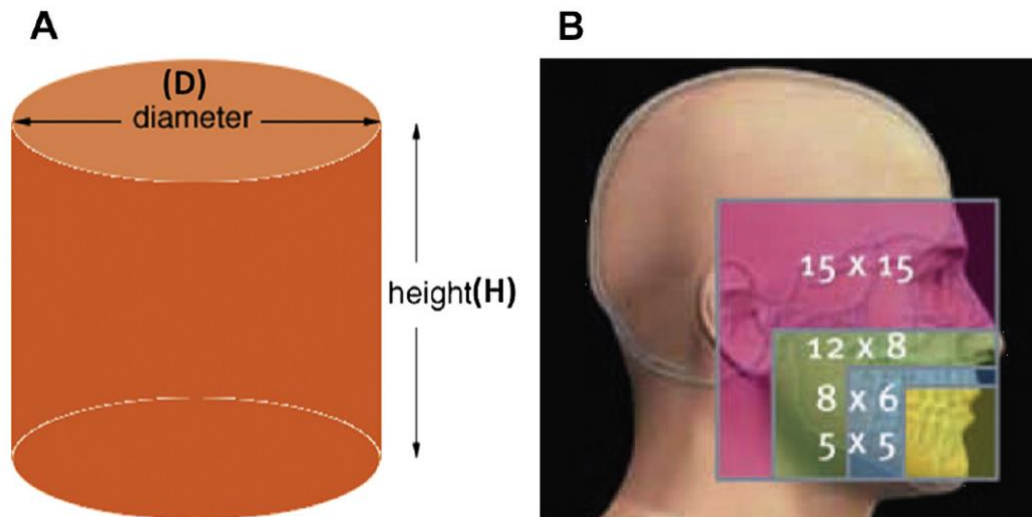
(A) Cylindrical shape and measurement characteristics of the field of view (FOV) for CBCT. (B) The different FOV option sizes (Abramovitch and Rice, 2014).
